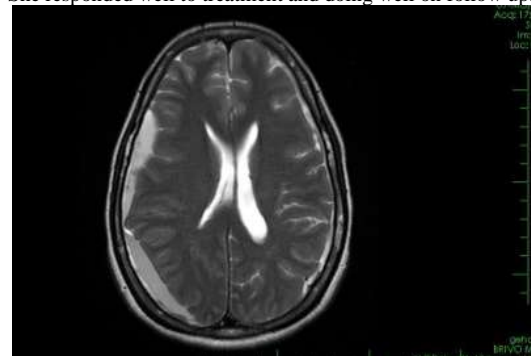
MRI brain showing subdural bleed extending from high parietal to occipital region with mild cerebral edema
